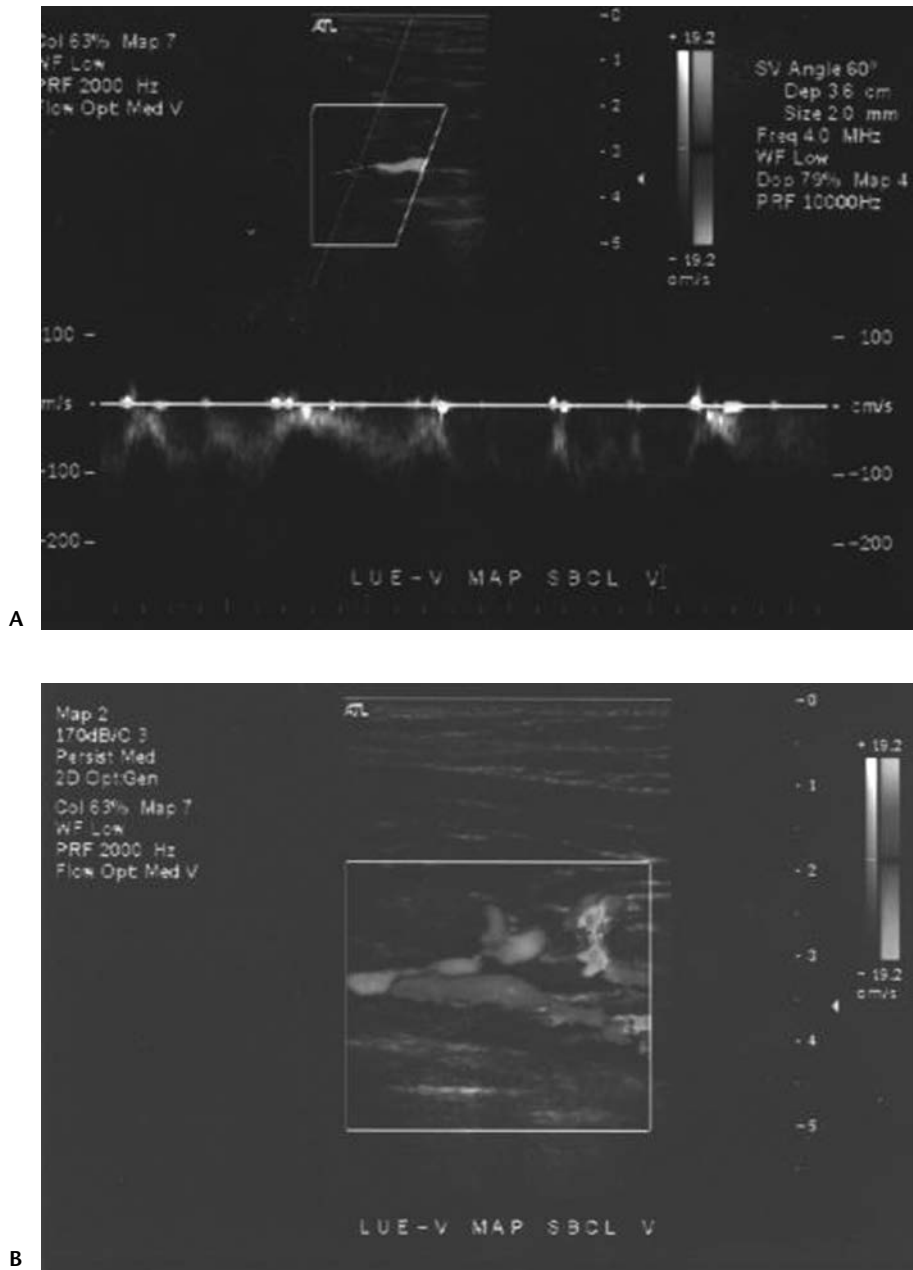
Abnormal appearance of left subclavian venous color-flow Doppler images.
